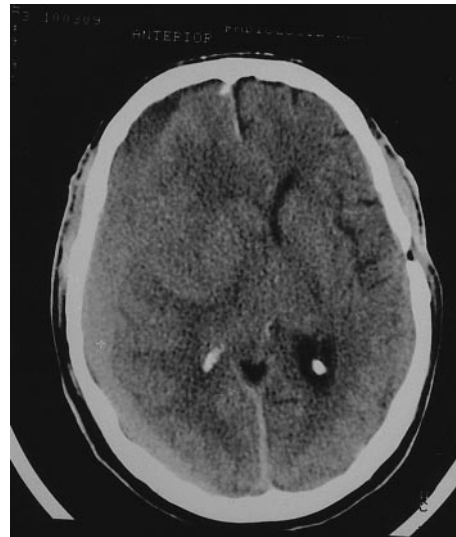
Axial computed tomography scans of a 82-year-old patient with Parkinson's disease reveal a rightsided subacute/chronic subdural haematoma with marked compression resulting in an increase of parkinsonian symptoms and signs, more pronounced on the left side
